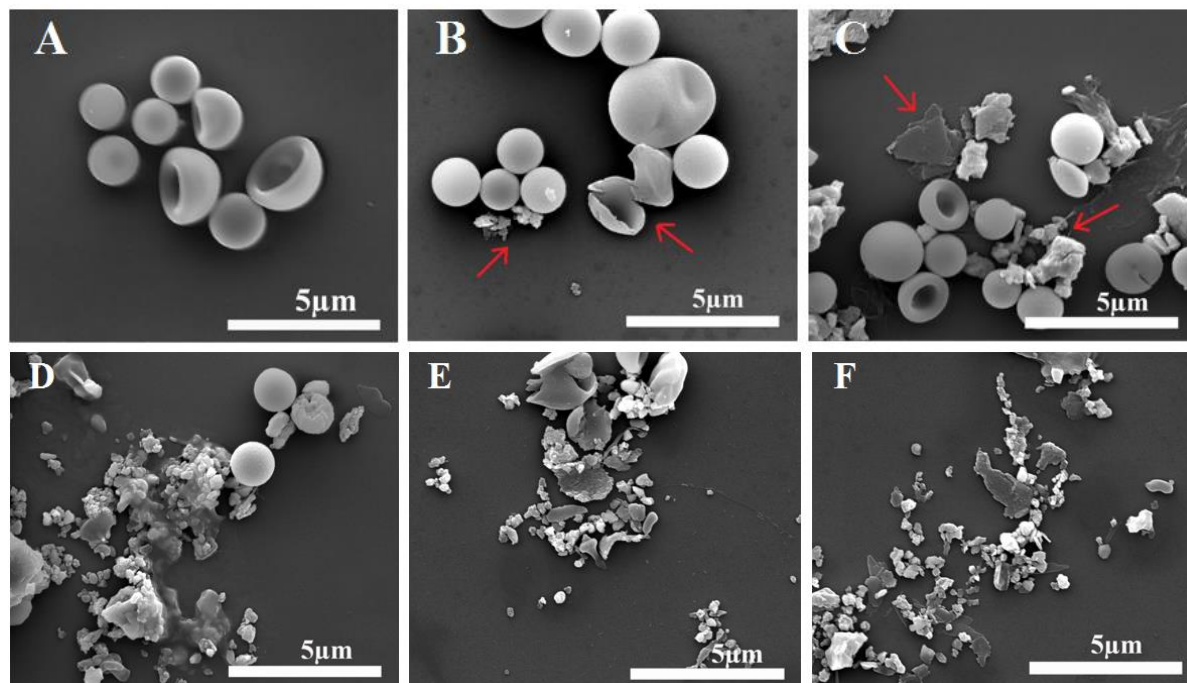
Characterization of ultrasound sensitivity. SEM images of PAH/PSS/CDs capsules treated with ultrasound for different duration time (A) 0 s; (B) 2 s; (C) 10 s; (D) 20 s; (E) 60 s; (F) 120 s.
